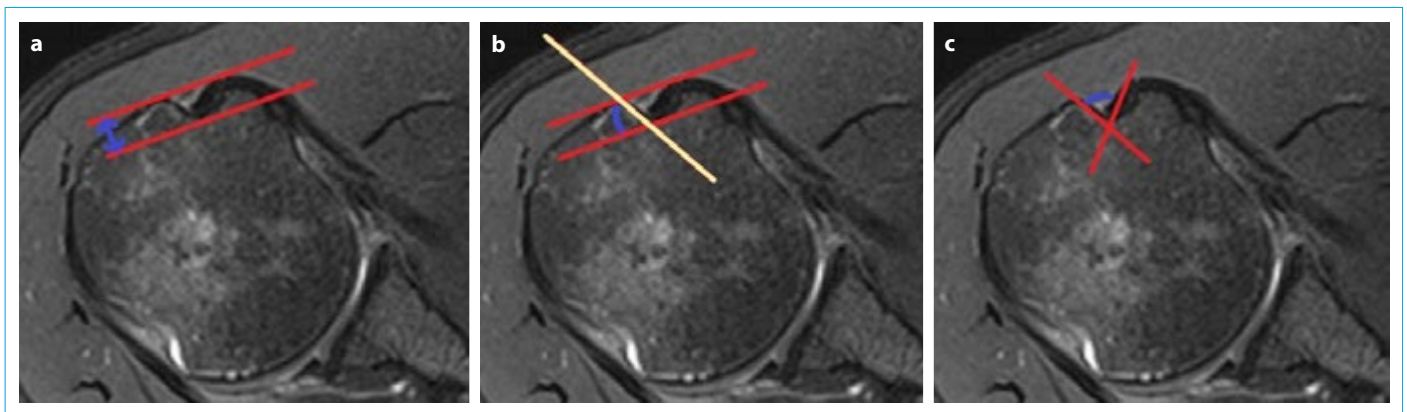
Axial magnetic resonance imaging sections through bicipital groove demonstrating the measurement methods of the bicipital groove depth (a) is the vertical blue distance between red lines, the medial wall angle (b) is the blue angle between the yellow line that cuts the parallel red lines and the total opening angle (c) is the blue angle between red lines.
